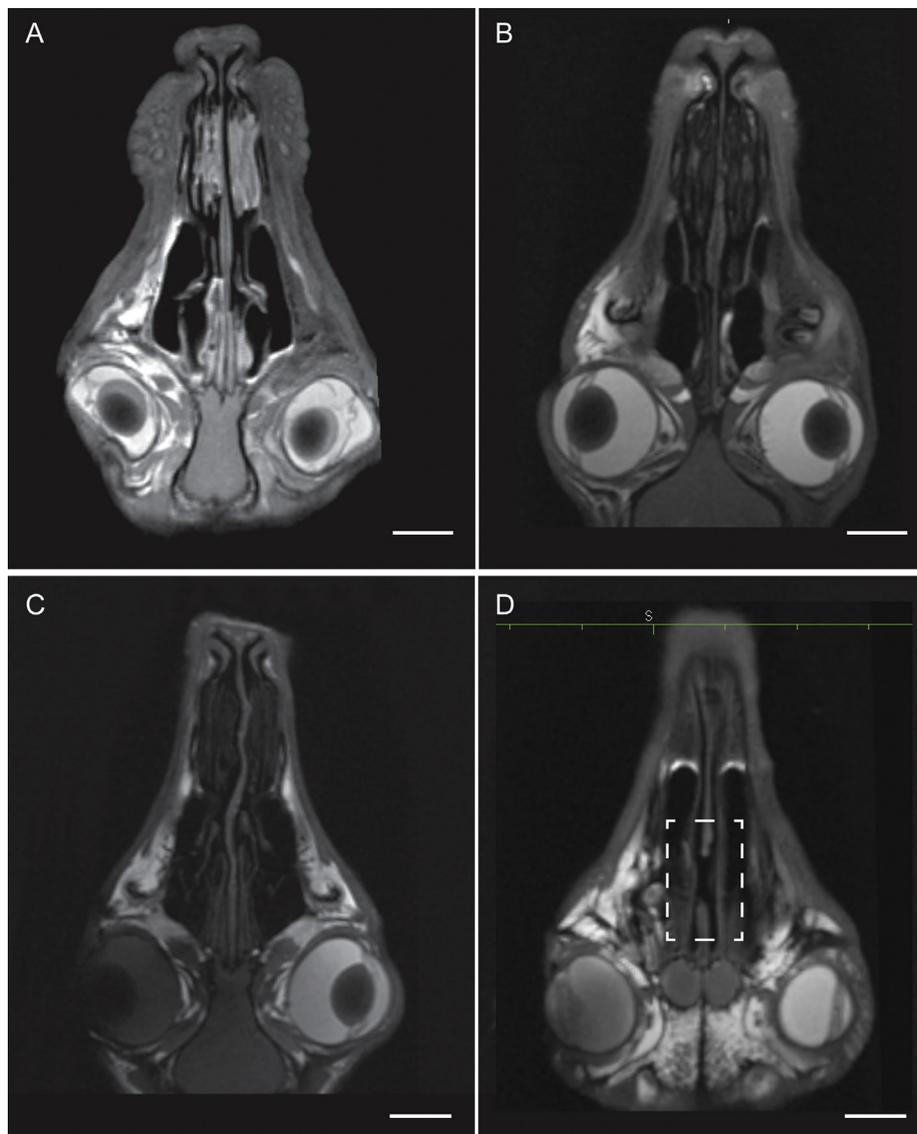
7-Tesla MRI of the septal implants after 6 months. A: native cartilage. B: decellularized cartilage. C: seeded decellularized cartilage with septal deviation. D: septal defect without replacement with septal perforation. Index = 1 cm.
